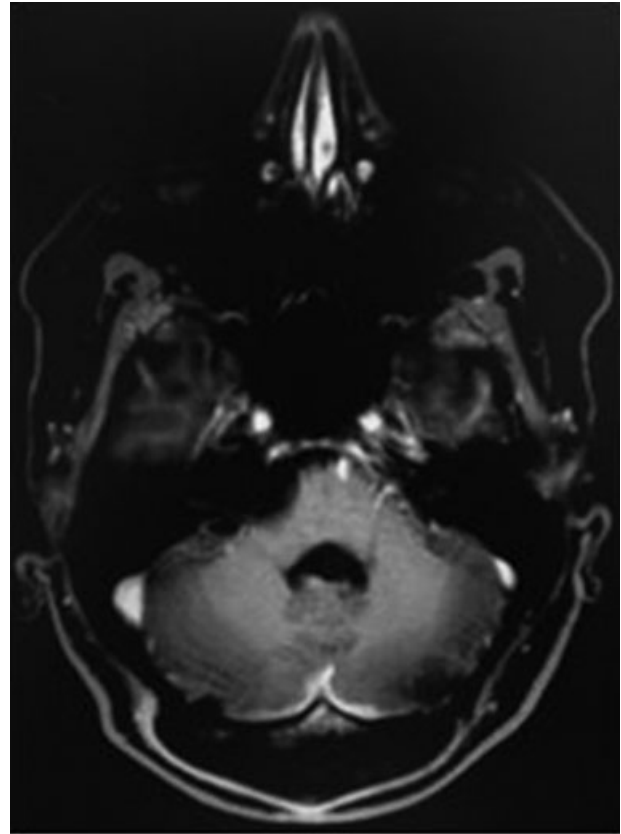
Postoperative encephalon T1-weighted MRI scan with contrast in the axial section, showing complete resection of the tumor lesion, with centralization of the brainstem and free fourth ventricle.
